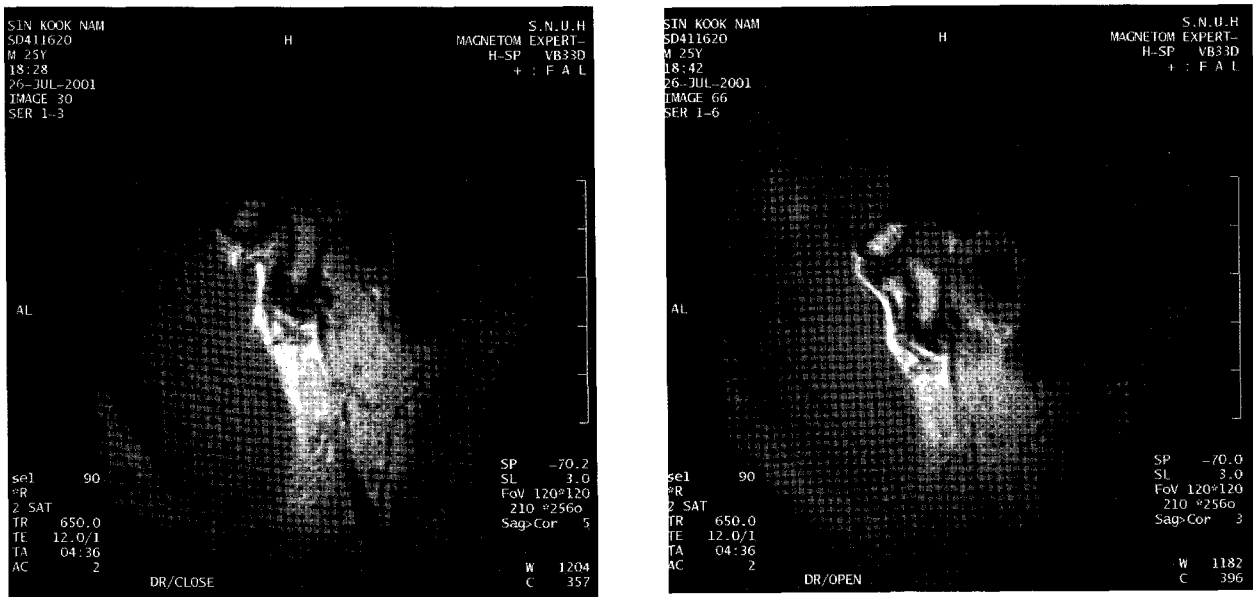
MRI analysis – ADD without reduction and abnormal disk morphology (left : closed state, right : open stste).
